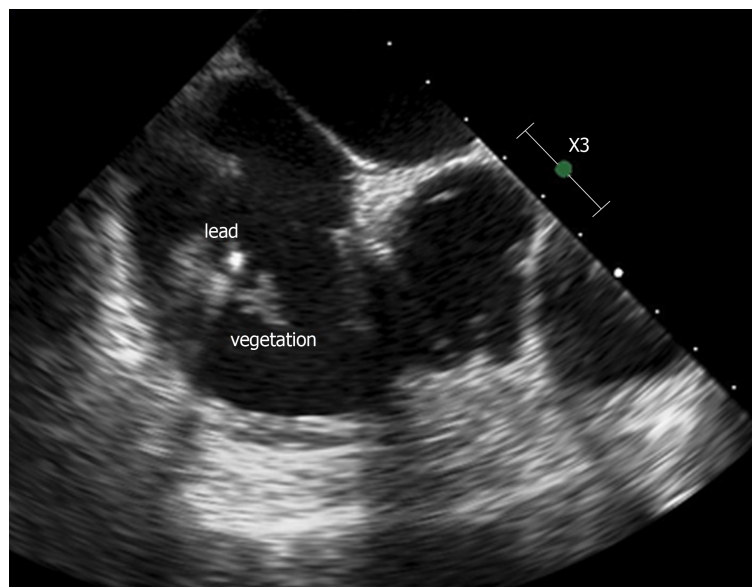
Transoesophageal echocardiography showing a defibrillator lead vegetation of 16 mm × 8 mm.
